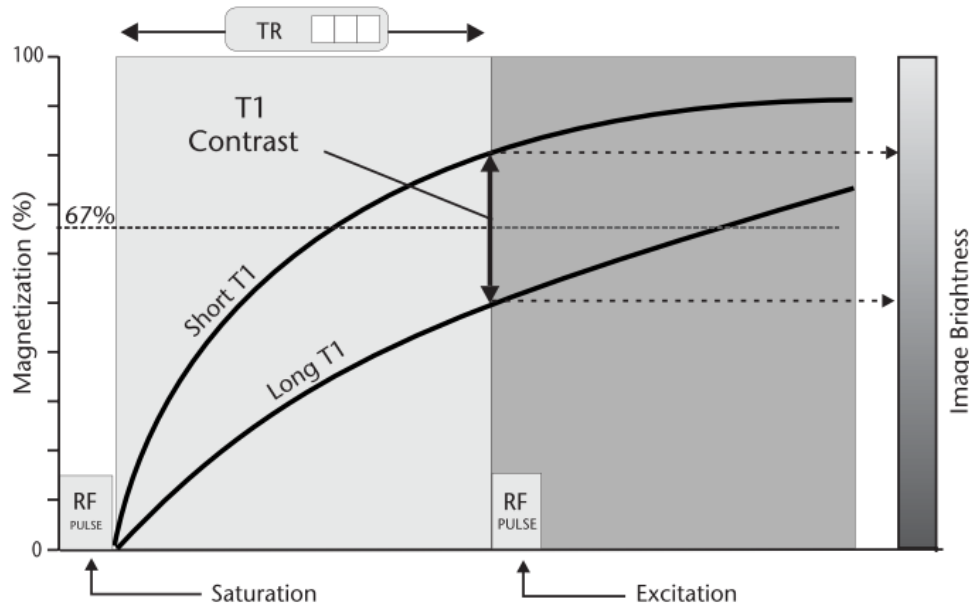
T1 weighted MRI imaging. Taken from Sprawls.⁴⁶
